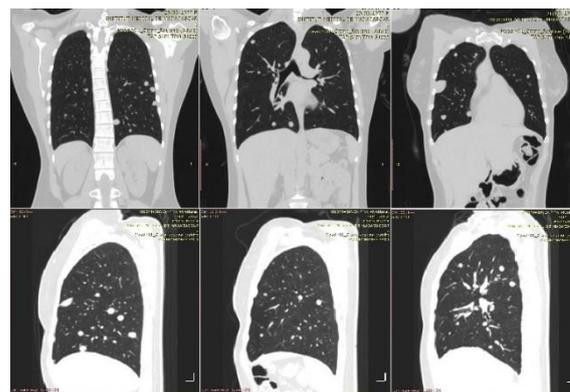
Computed tomography demonstrates a diffuse distribution of multiple well-defined non-calcified pulmonary nodules.
